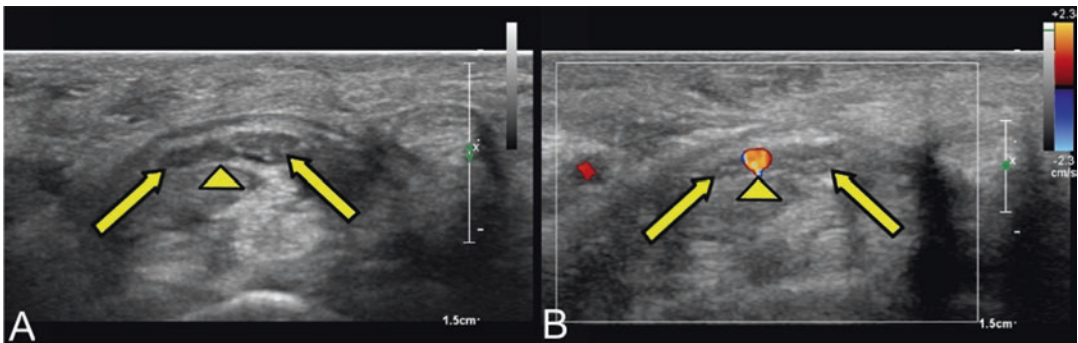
Axial ultrasound image 2D gray scale (a) and color Doppler (b)—Bifid median nerve (yellow arrow) with persistent median artery (arrowhead)
